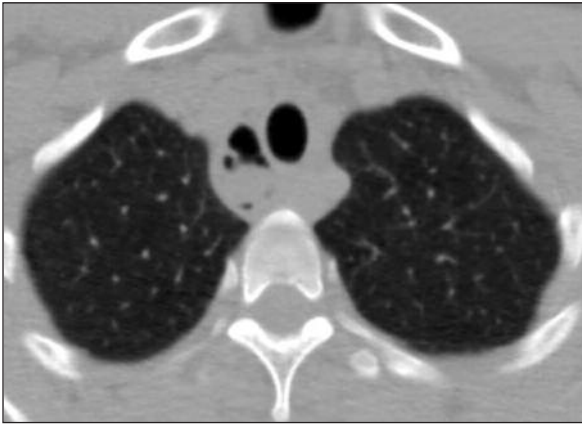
Chest CT scan shows paratracheal air cyst posterolaterally of the trachea.
